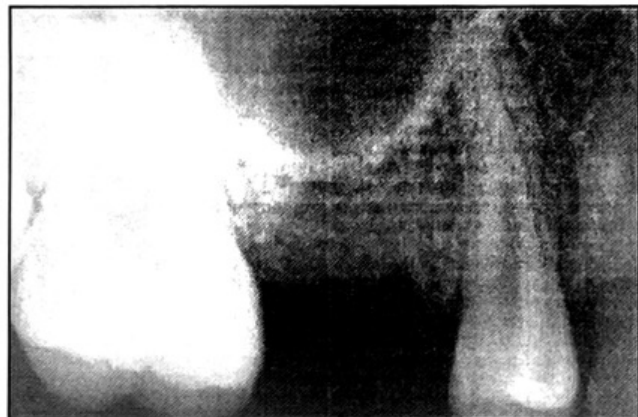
Preoperative periapical radiographs of right deciduous second premolar showing insufficient alveolar bone for implant-supported restorations.
